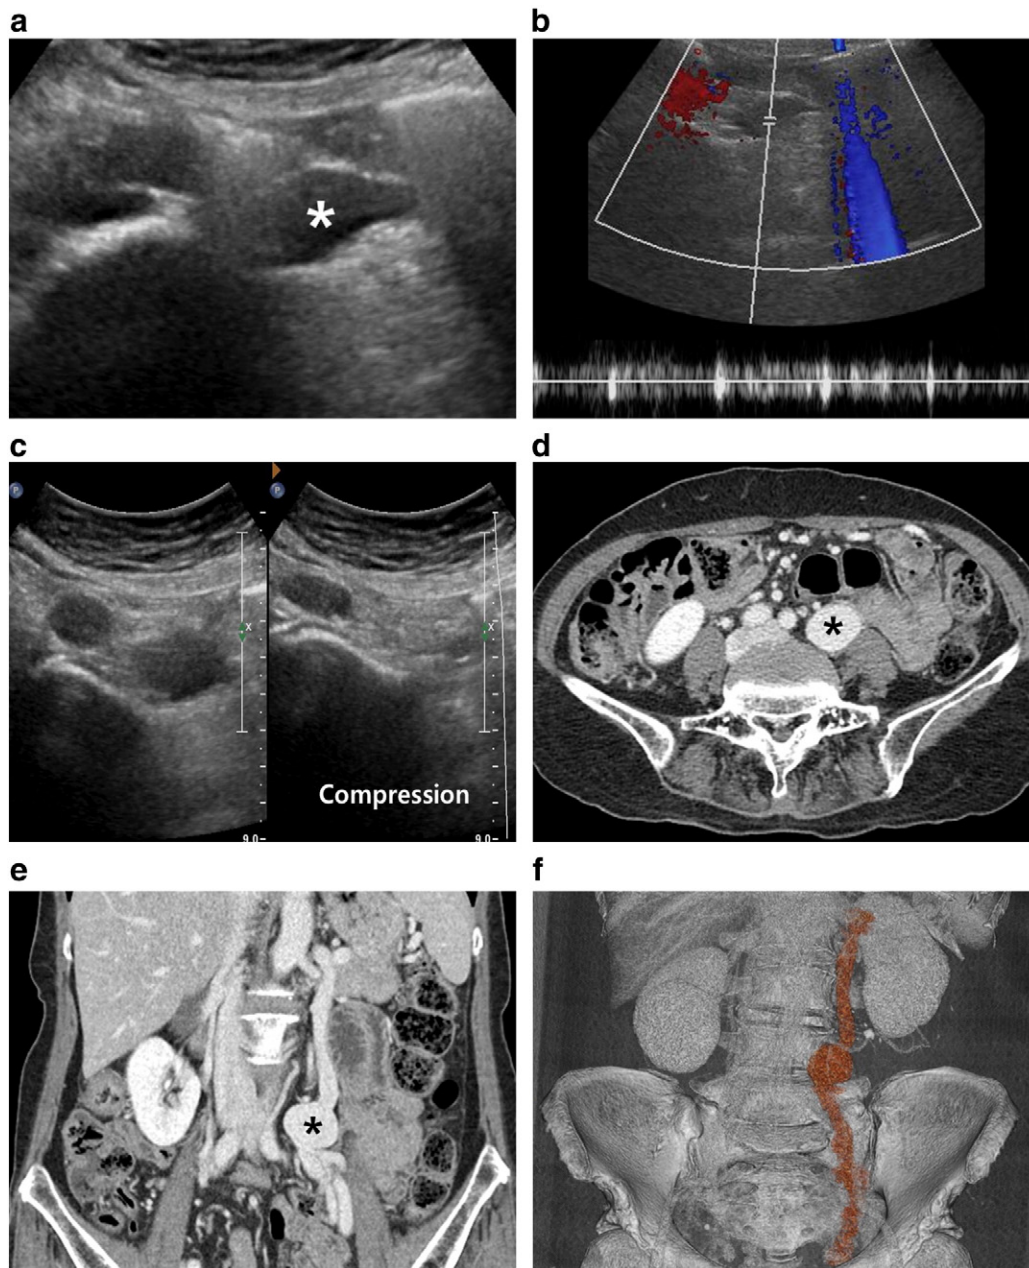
Case 1. (a and b) Grayscale (a) and pulsed Doppler (b) US show an anechoic sacular structure (*) with internal venous flow. (c) This structure collapsed with manual compression and was proven to be a vein (left side). (d and e) Venous phase of an axial image (c) and coronal reformatted image (d) of contrast-enhanced CT show aneurysmal dilatation (*) and a tortuous appearance of the left ovarian vein. (f) Volume rendering reconstructed image demonstrates the course of the left ovarian vein with aneurysmal dilatation.
